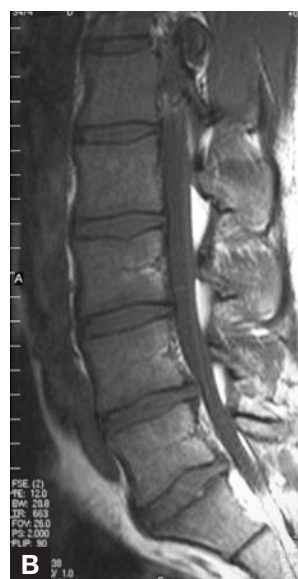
Preoperative magnetic resonance imaging: (A) Axial scan shows left-side paracentral L4–L5 disc herniation where patient developed left L5 radiculopathy; (B) sagittal scan shows disc herniation at L4–L5 level consistent with contained disc displacement.
